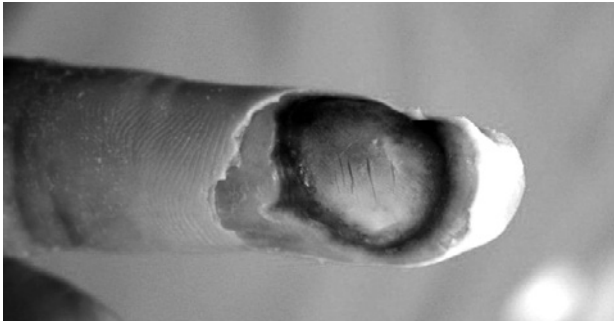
A third-degree burn on the distal phalanx caused by an MR-unsafe pulse oximetry probe on a patient during MR imaging. Reprinted under the Creative Commons Attribution Non-Commercial License 4.0. Sung SJ, Park YS, Cho JY. Full thickness burn on the finger due to pulse oximetry during magnetic resonance imaging in a conscious patient. *Arch Plast Surg.* 2016.43(6):612-613. doi:10.5999/aps.2016.43.6.612. creativecommons.org/licenses/by-nc/4.0/
